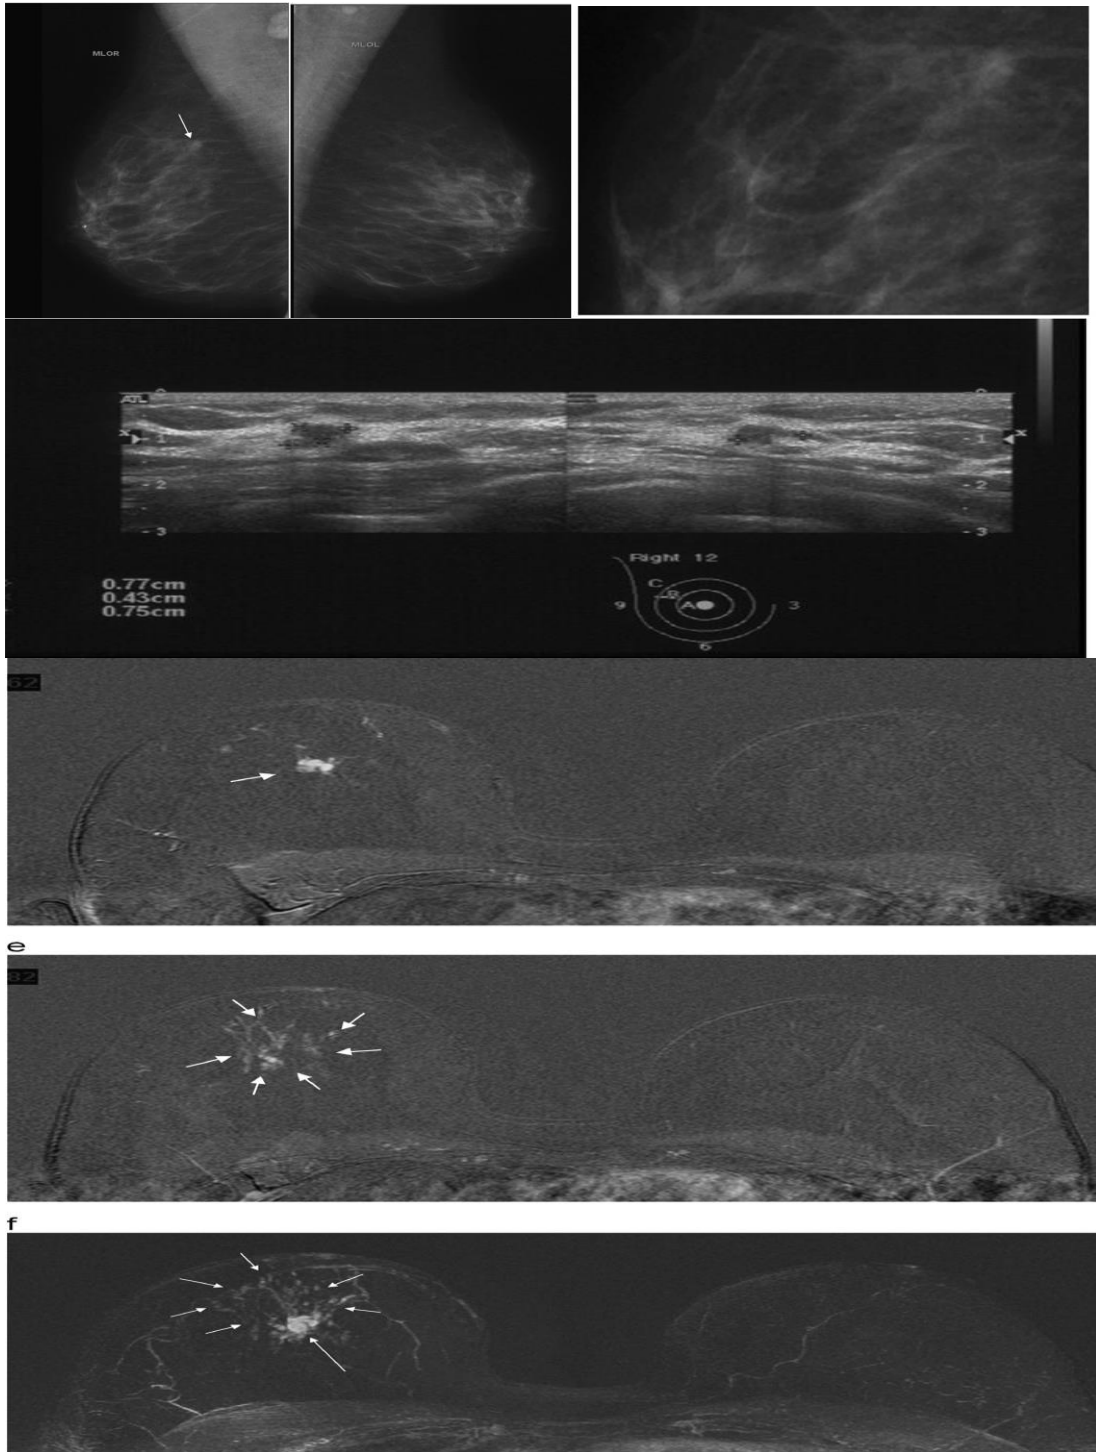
(a): -A large cancer cell presents on right breast in MRI images [182].
